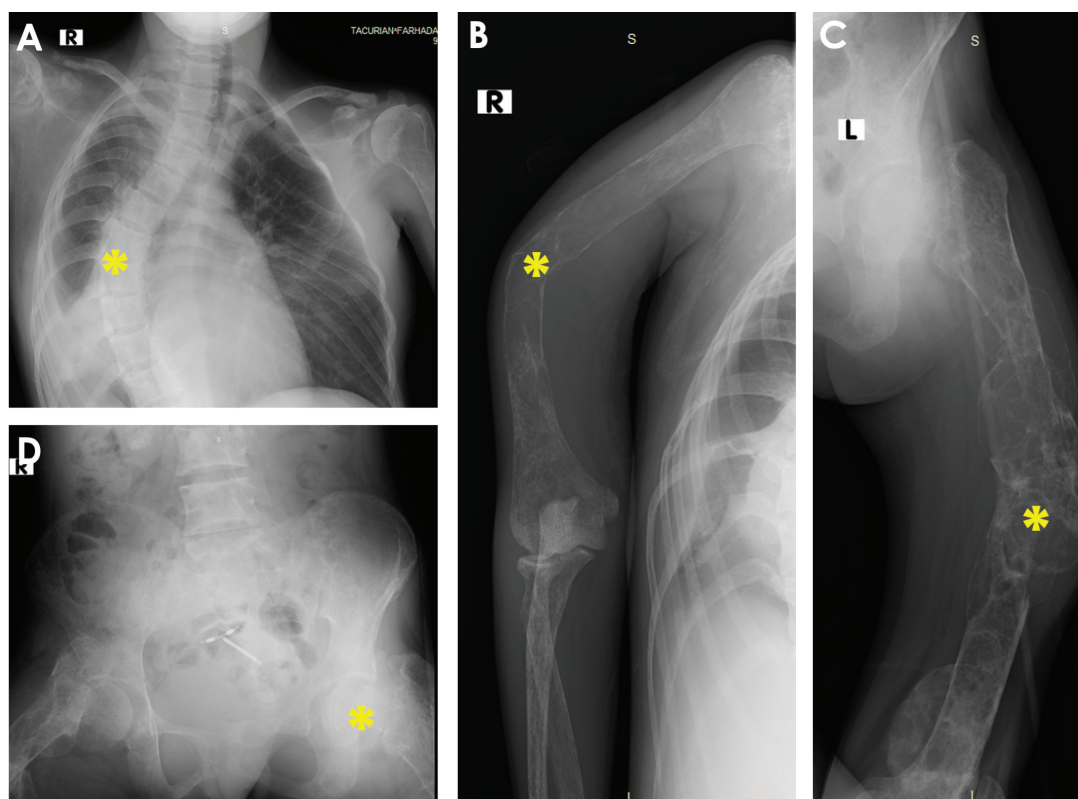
Multiple abnormal radiologic findings: (A) Chest radiography, postero-anterior view revealed severe lower thoraco-lumbar dextroscoliosis; (B) Humerus, antero-posterior view revealed pathologic fracture with angulation and impaction in the right humerus (*) with diffuse osteopenia; (C) Thigh, antero-posterior view showed pathologic fracture of the left femur with expansile osteolytic changes along the midshaft and distal posterior aspect; and (D) Pelvis radiography, anterior-posterior view revealed right femoral neck pathologic fracture (*) and mixed osteolytic-blastic changes.
